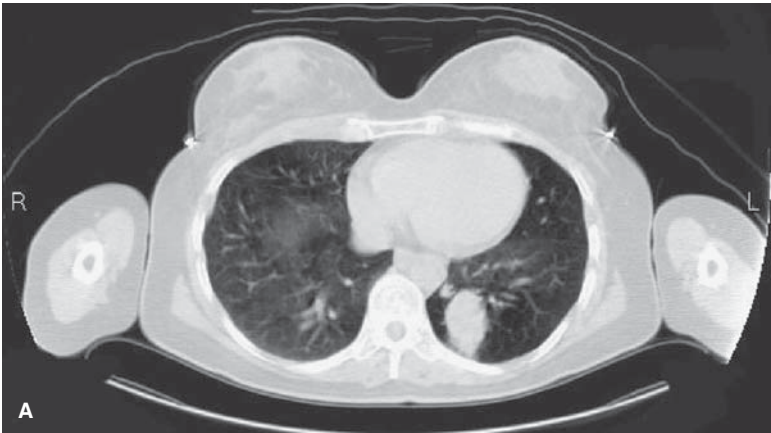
Bronchial carcinoid (A and B). FDG-PET/CT images demonstrate a mass measuring 3.5×2.7 cm in the left lower lobe. The mass has an SUV of 2.1 and is similar in intensity to the activity of the mediastinal blood pool. This degree of activity, although non-specific, suggests a benign inflammatory etiology. The patient subsequently underwent resection and surgical pathology revealed well-differentiated neuroendocrine carcinoma with endobronchial extension. (Case courtesy of Ronald B. Workman, Sr., MD.)
